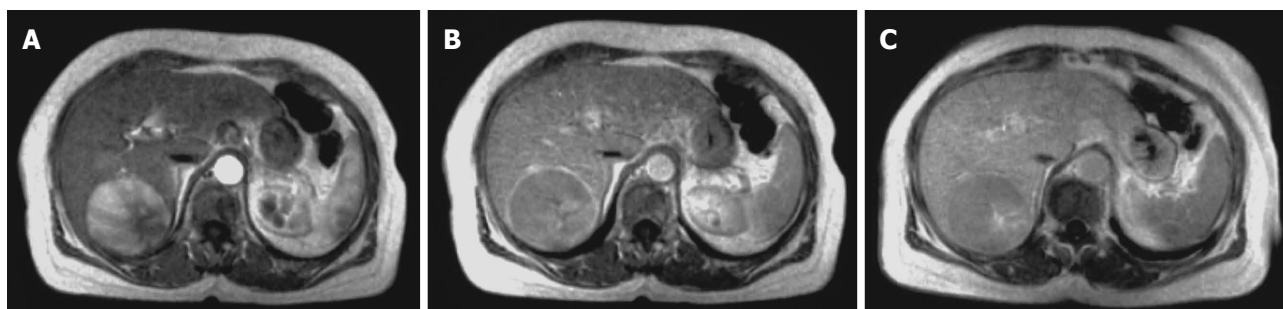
Typical hepatocellular carcinoma at magnetic resonance imaging: contrast enhancement in arterial phase (A) and washout in venous (B)/late (C) phase.
